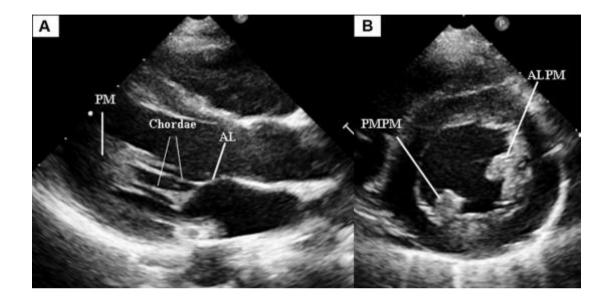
2-dimensional echocardiography in a healthy adult. (A) Parasternal longaxis view showing subvalvular apparatus anchored to the anterior mitral valve leaflet. (B) Parasternal short-axis view showing anterolateral and posteromedial papillary muscles. AL: anterior leaflet; PM: papillary muscle; PMPM: posteromedial papillary muscle; ALPM: anterolateral papillary muscle (Séguéla, Houyel, and Acar, 2011)
